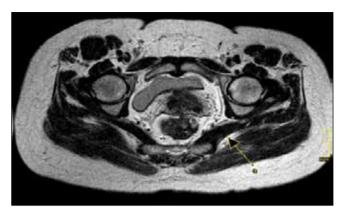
Pelvic magnetic resonance imaging. a: Asymmetric thicker appearance of left piriformis muscle, according to the right.
